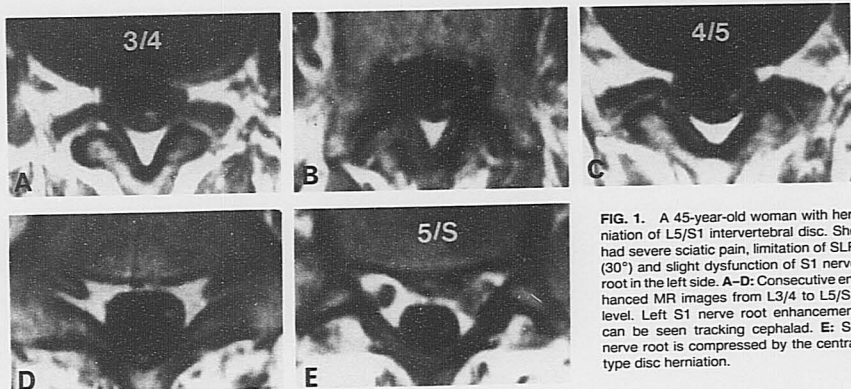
A 45-year-old woman with herniation of L5/S1 intervertebral disc. She had severe sciatic pain, limitation of SLR ( $30^\circ$ ) and slight dysfunction of S1 nerve root in the left side. A-E: Consecutive enhanced MR images from L3/4 to L5/S1 level. Left S1 nerve root enhancement can be seen tracking cephalad. E: S1 nerve root is compressed by the central type disc herniation.
